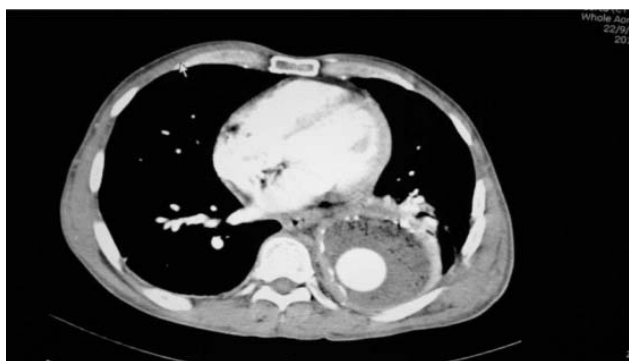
CT scan shows presence of air bubbles surrounding aorta graft indicating abscess formation.
